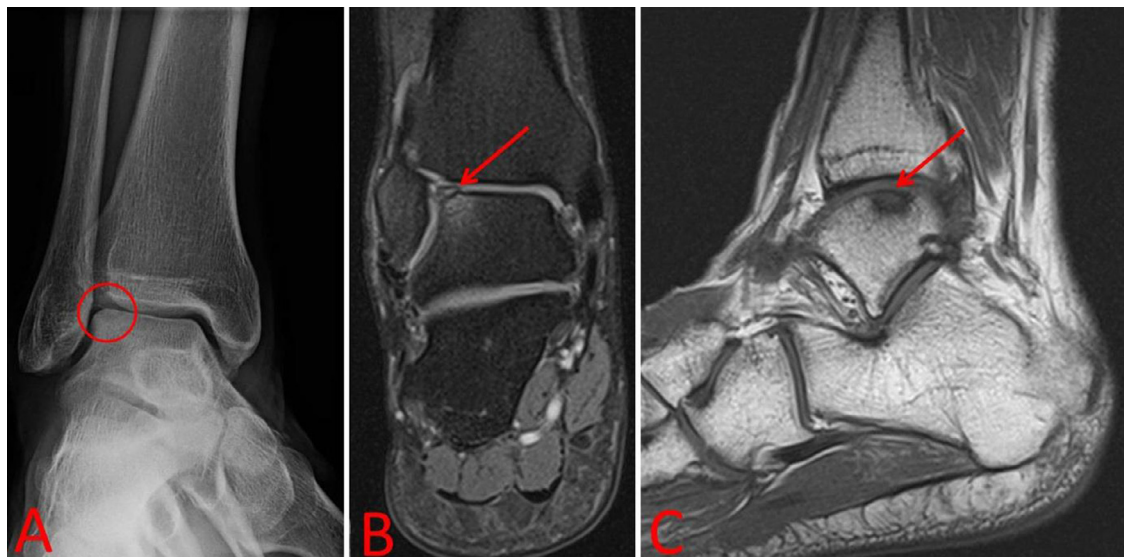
Radiographic image (A) and T2-weighted coronal (B) and T1-weighted sagittal (C) magnetic resonance scans showing a lateral osteochondral lesion of the talus with subchondral collapse.
